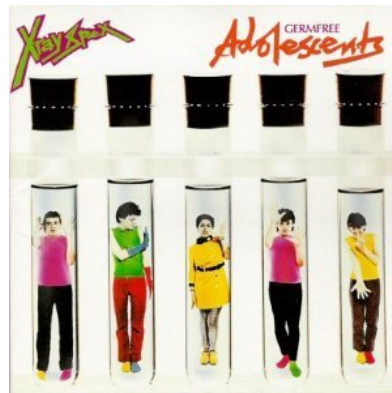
Cover art for *Germfree Adolescents* (X-ray Spex).
